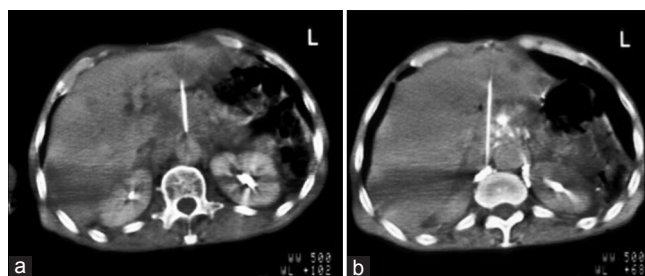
(a) A single transhepatic needle is placed at the level of the celiac axis. (b) Computed tomography section slightly higher showing a transhepatic needle placement for a right splanchnic plexus neurolysis after contrast was injected through the single celiac needle and the left splanchnic and the right splanchnic needles demonstrating satisfactory distribution
